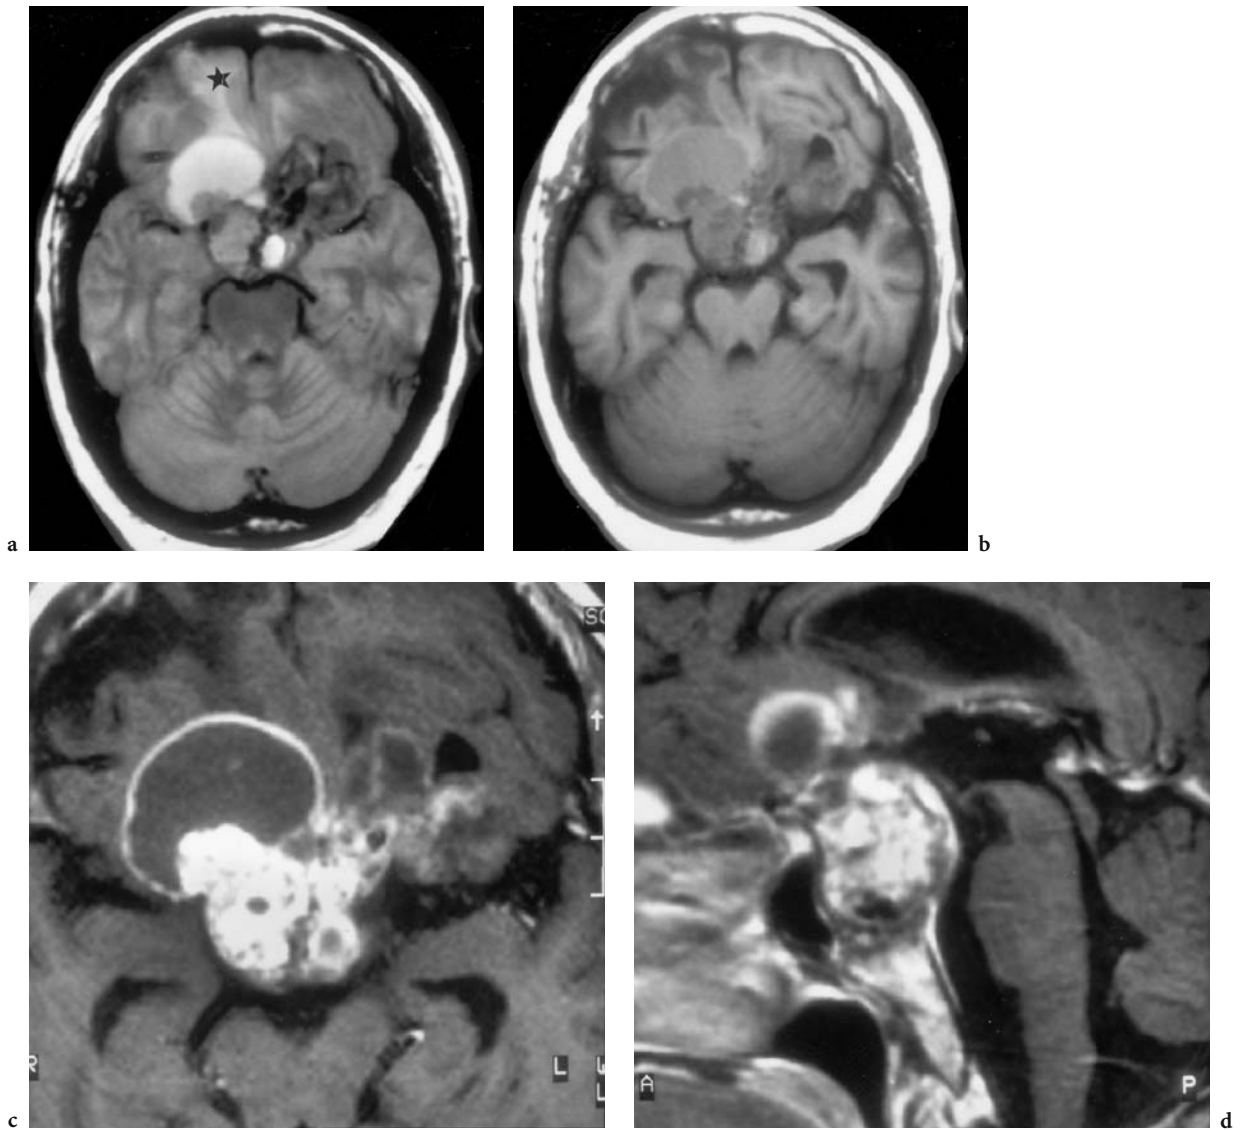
MRI of a 20-year-old woman suffering from headache and visual deficit of both eyes, with dominance of the right side. Diagnosis: recurrent craniopharyngioma. MRI: a axial proton density view with inhomogeneous signal patterns of a bilateral, primarily median, frontal tumor. Note that the hyperintense cyst on the right side exhibits a more intense signal than the CSF of the right frontobasal parenchymal defect (*star*) after initial operation. b Corresponding T1-weighted native view demonstrating an intermediate signal of the cystic area, which is accounted for by the protein content of the cyst. c Enlarged corresponding T1-weighted, contrast-enhanced view where the cystic wall as well as the solid regions of the tumor exhibit strong signal enhancement. d Midsagittal, T1-weighted, contrast-enhanced T1-weighted view with widening of the sella and depression of the floor of the third ventricle and of the inferior frontal lobe by the tumor cyst. Neither chiasmatal nor pituitary stalk structures can be differentiated
